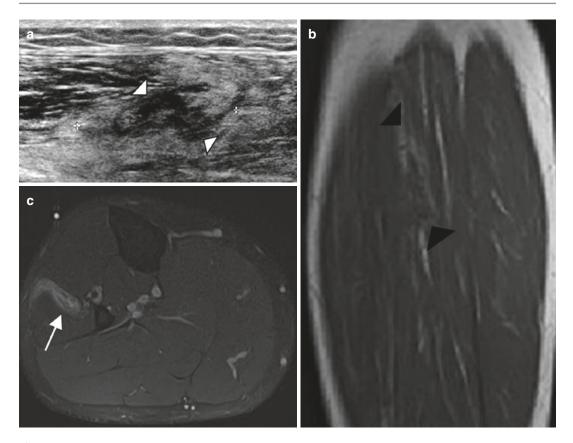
Intramuscular venous malformation of the thigh in a 32-year-old man with pain exacerbated during exercise. (a) Ultrasound. (b) Sagittal T1-weighted MR image. (c) Axial T1-weighted MR image after Gadolinium contrast administration, with fat suppression (a)
